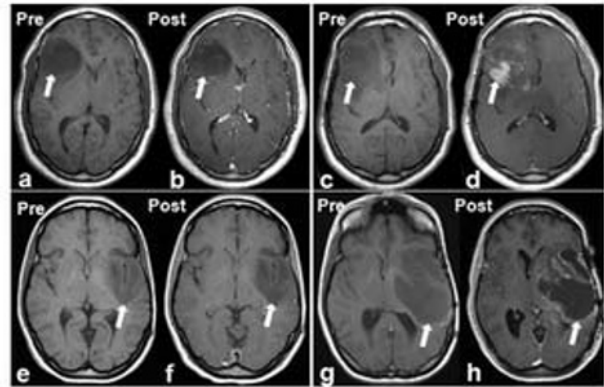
Contrast enhanced MRI of two examples of low grade tumors harboring IDH mutation progressed to GBM (Grade IV) revealed the low signal lesion on pre T1WI (a, e) and no enhancement on post contrast T1WI (b, f). Two years later, same case showed the increased tumor size on T1WI (c, g), and strong contrast enhancement on post T1WI (d, h).
